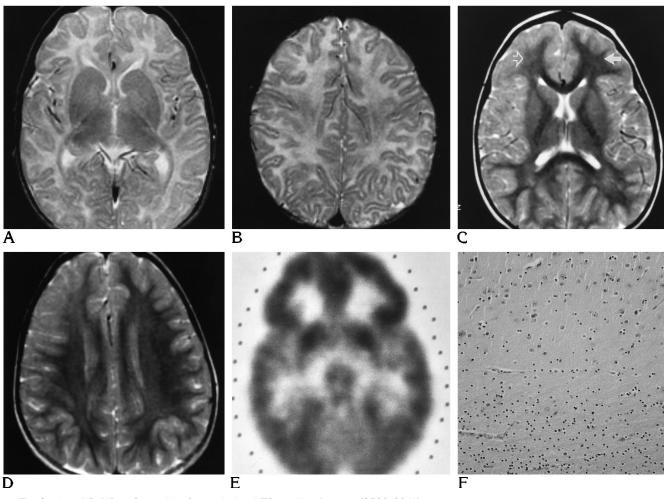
A and B, MR at 6 months of age. A, Axial T2-weighted image (2500/80/1) at the level of the internal capsule. The gray matter–white matter boundary is well delineated, and there is no inequality of distribution of white matter.
